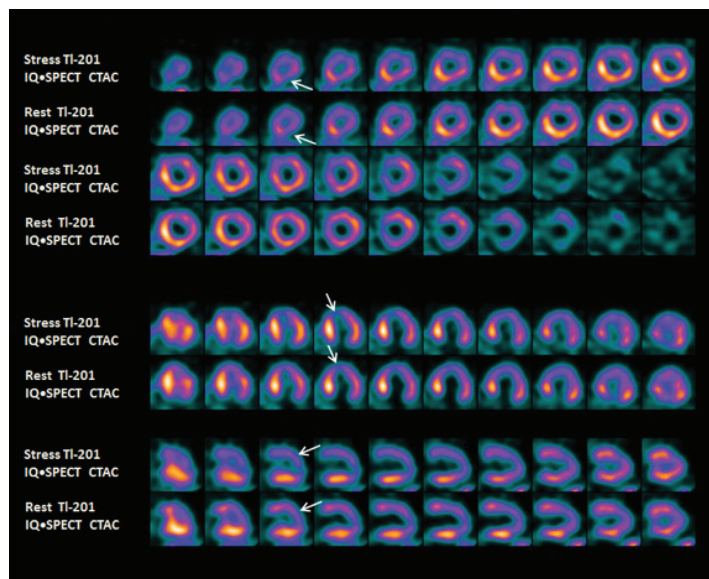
Stress/rest, attenuation-corrected  $^{201}\text{Tl}$  IQ•SPECT myocardial perfusion study shows heterogeneous tracer distribution in the anterior wall and slight anterolateral ischemia near the apex.
